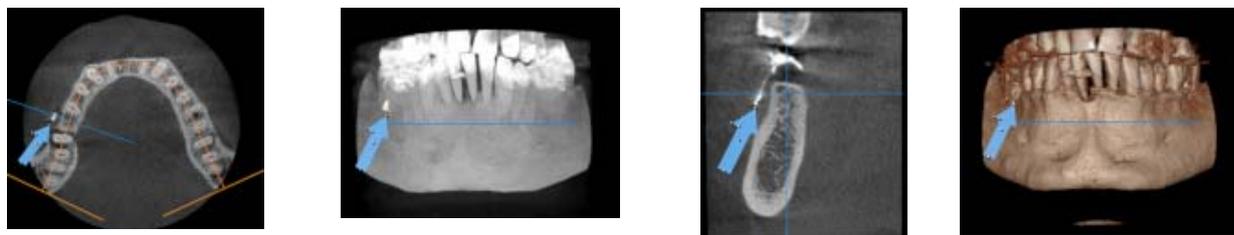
(a), (b) Radiographic aspect, (c) radiographic detail, and (d) 3D reconstruction after inserting the BaSO₄ solution in the periodontal pockets
